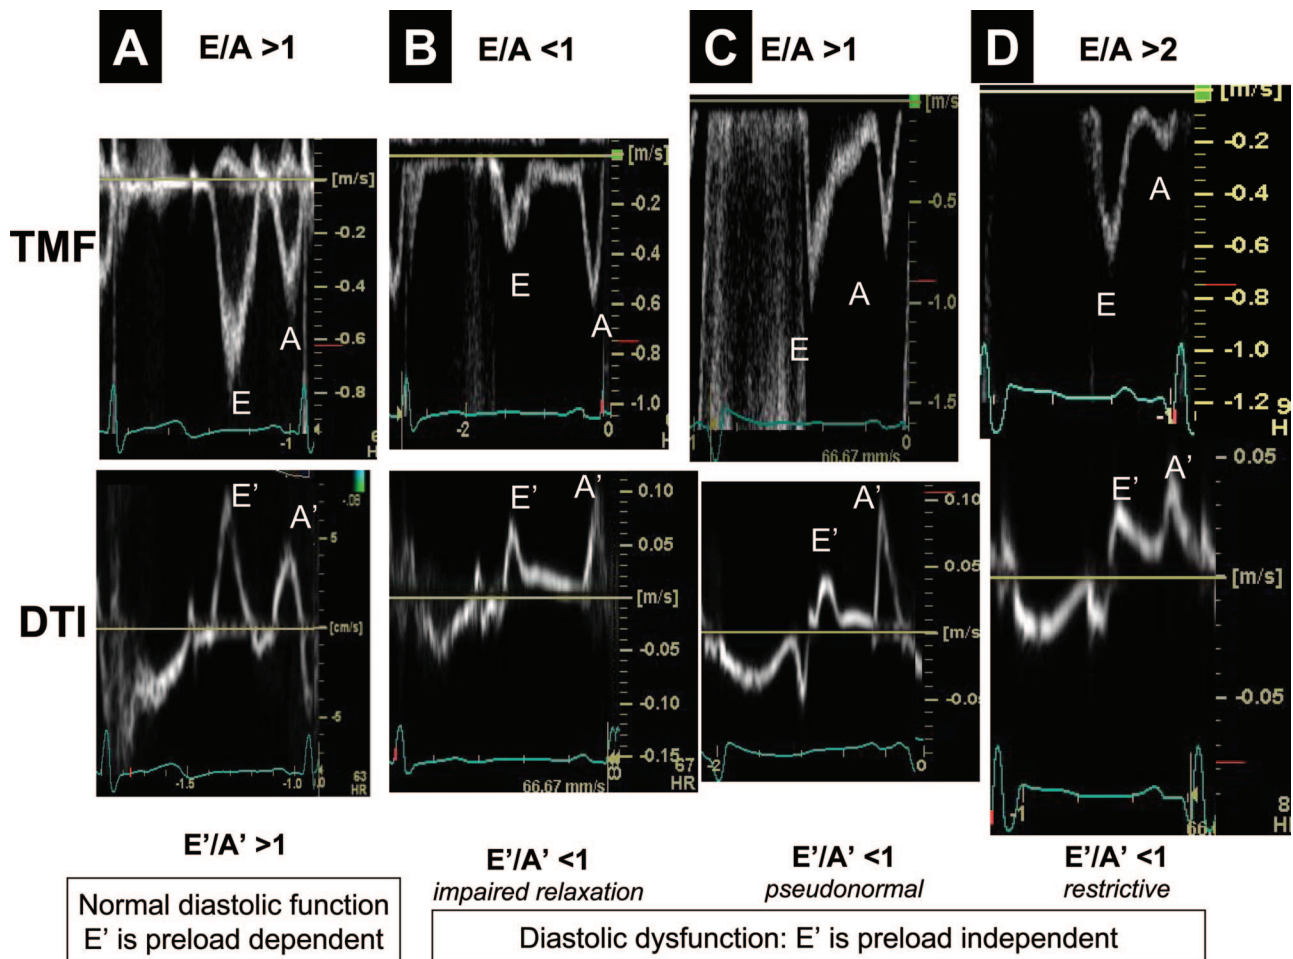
Evaluation of diastolic function with Doppler tissue imaging (DTI). A DTI ratio $E'/A' < 1$ is abnormal and used to differentiate between normal and pseudonormal transmitral flow (TMF) patterns. (A) Normal diastolic function: $E/A > 1$ and $E'/A' > 1$. (B) Impaired relaxation: $E/A < 1$ and $E'/A' < 1$. (C) “Pseudonormal” pattern: $E/A > 1$ and $E'/A' < 1$. (D) Restrictive pattern: $E/A > 2$ and $E'/A' < 1$.
